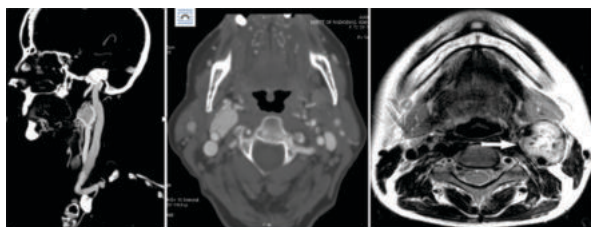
Fig a,b CT angio neck of 35 year old male with intensely enhancing mass in neck causing splaying of ICA and ECA with encasement
